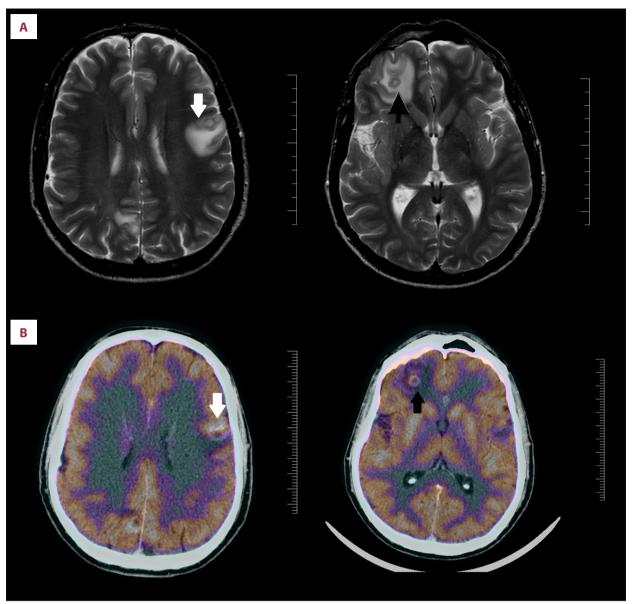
Cranial images showing space-occupying lesions suggestive of brain abscesses. (A) Cranial magnetic resonance imaging of the brain showing increased signal in T2-weighted of the right parietal lobe (white arrow) and left frontal lobe (black arrow).
